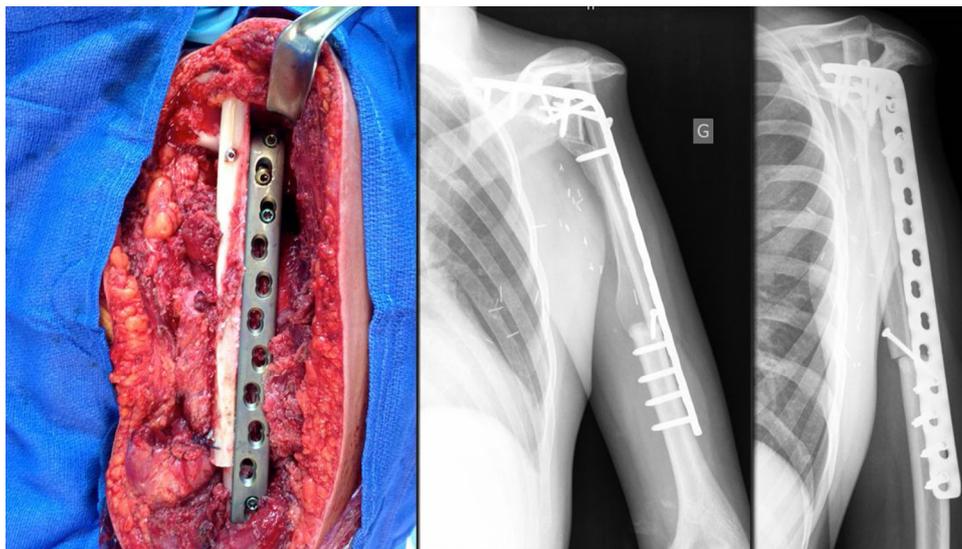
Intraoperative image and 3-month postoperative radiographs of a shoulder arthrodesis performed with vascularized scapular pillar and autologous fibular graft.
